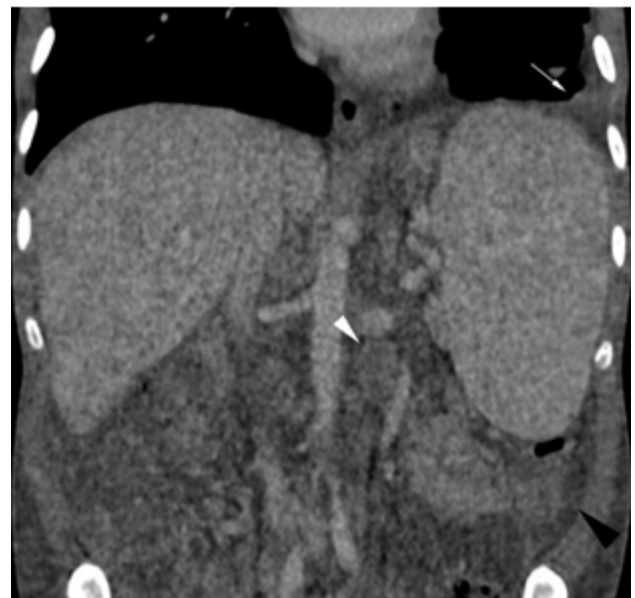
Computed tomography with ionic contrast of thoraco-abdominal region. White arrow points to left pleural effusion, white arrow-head indicates to 3 cm retro-peritoneal lymph node, black arrow-head shows ascitic fluid. Note splenomegaly.
